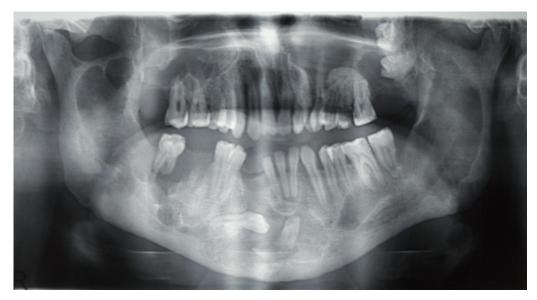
Panoramic X-ray showed osteolytic change and destruction of the cortical bone
